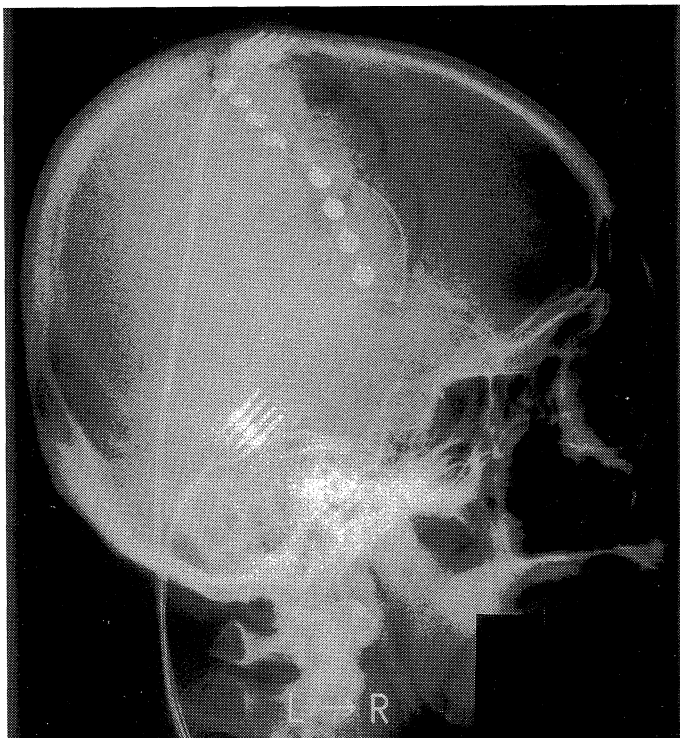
Roentgenogram shows permanent implantation using two electric arrays.
